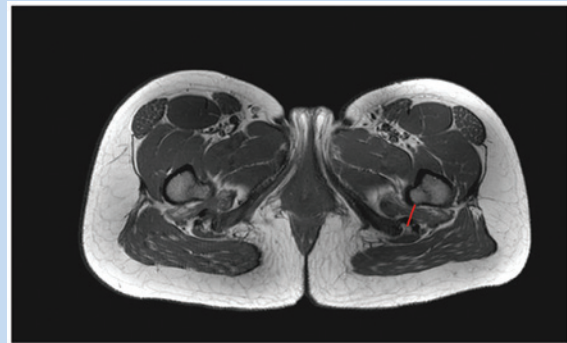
Ischiofemoral space. Hip magnetic resonance image, axial T1-weighted image. Red line, measurement of the ischiofemoral space; top, anterior; bottom, posterior; right, left; left, right.
